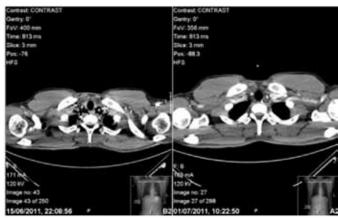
Computed tomography scan of chest with Gastrografin contrast; a comparison of image on admission image after resolution showing no surgical emphysema.
